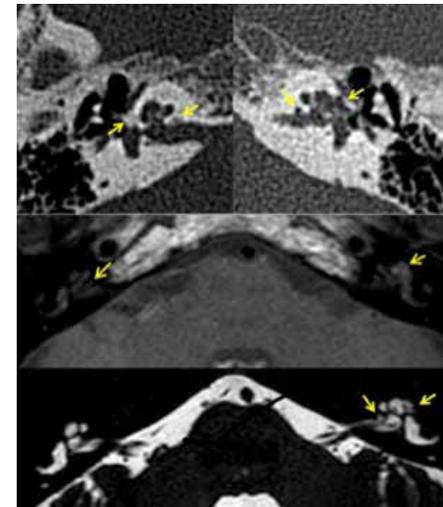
CT of a patient with fenestral and retrofenestral otosclerosis reveals otospongiotic foci on the right and mixed otospongiotic and lytic lesions on the left. On MR imaging the predominantly lytic lesions show an enhancing mass on T1 after contrast and T2 high signal intensity, whereas the small otospongiotic foci on the right are hardly seen.
